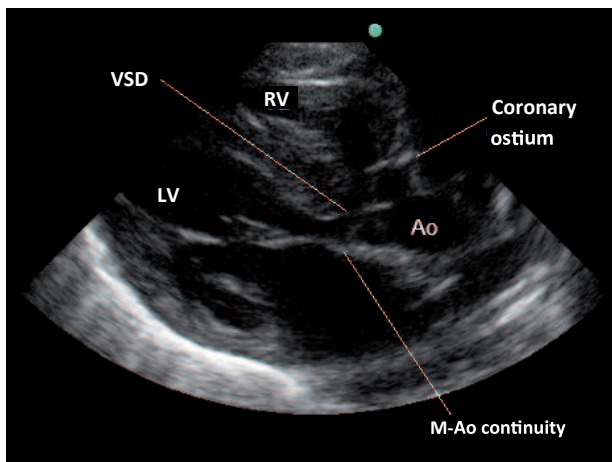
A & B. Long axis parasternal view. Case 1. Relationship between the ventricles and the great arteries. Aortic valve continuity with the anterior mitral leaflet and ventricular septal defect is observed. VSD: Ventricular septal defect. RV: Right ventricle. LV: Left ventricle. Ao: Aorta. MPA: Main pulmonary artery. M-Ao: Mitro-aortic. M-P: Mitro-pulmonary.
